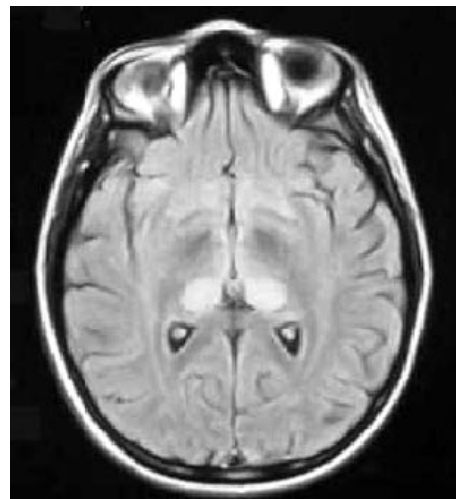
MRI (FLAIR sequence) of brain showing bilateral pulvinar high signal.
